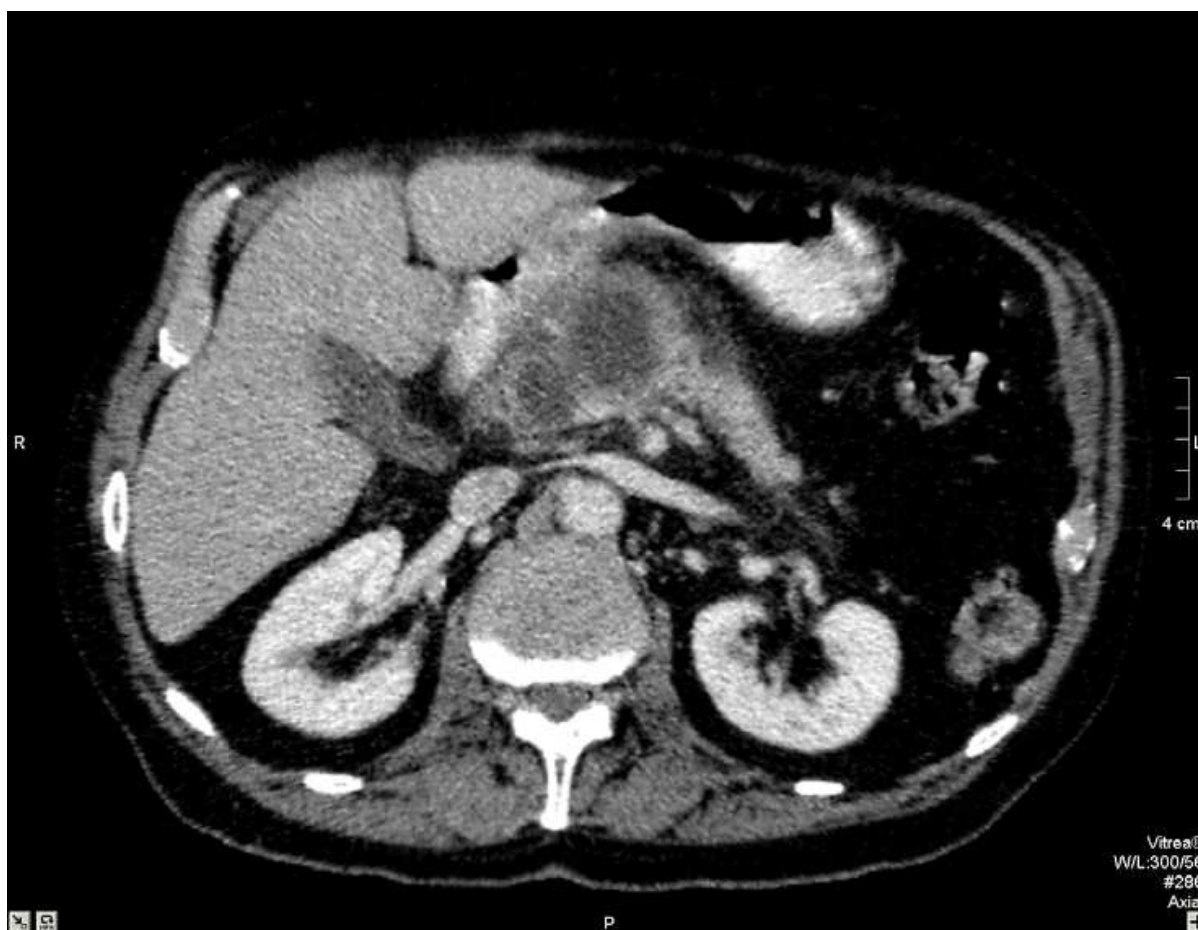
CT. Pancreatic cancer. Axial view.
